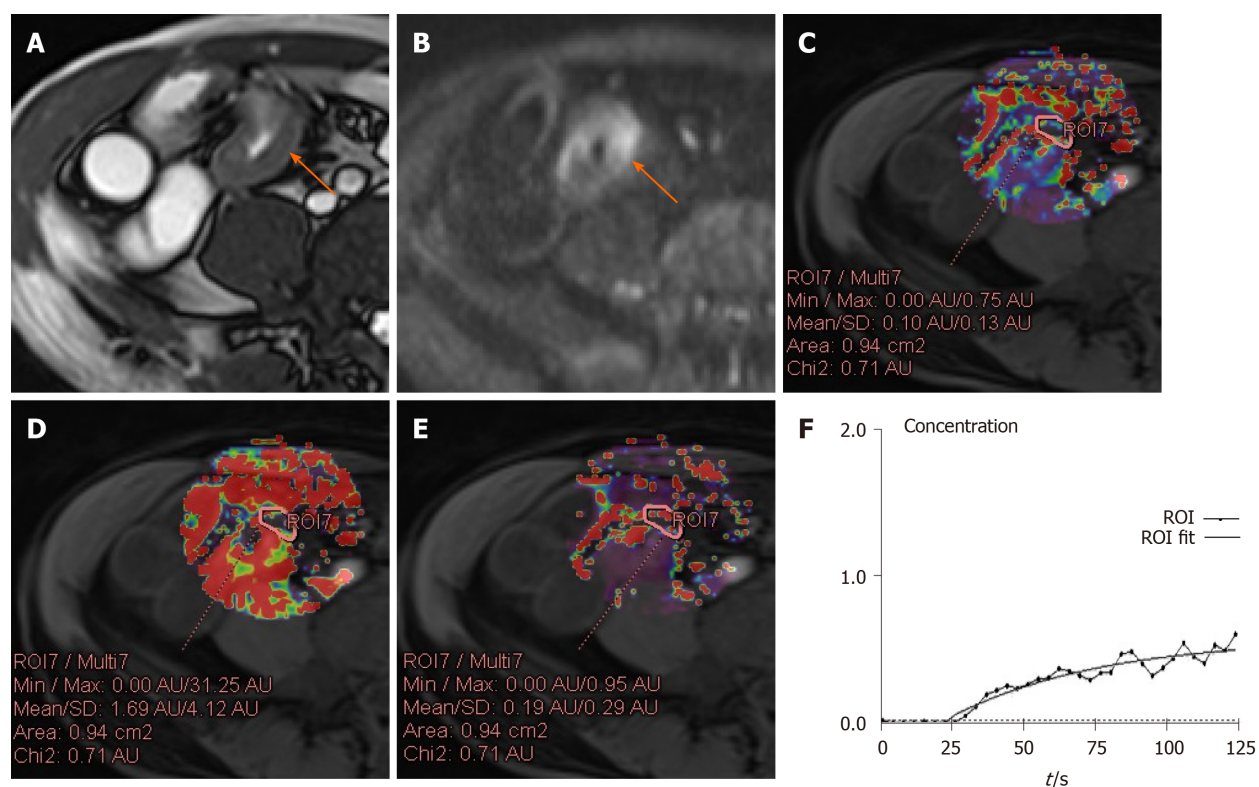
A 42-year-old male with remission of Crohn's disease in the terminal ileum and a Crohn's Disease Activity Index of 108 and Crohn's Disease Endoscopic Index of Severity of 2. A: Axial T2-weighted image shows mural thickening and hyperintensity in the terminal ileum (arrow); B: Axial diffusion-weighted imaging image ($b = 800 \text{ s/mm}^2$) demonstrates high signal (arrow) in the same bowel segment. Regions of interest (ROI) for the inflammatory bowel wall shows that apparent diffusion coefficient = $1.89 \times 10^{-3} \text{ mm}^2/\text{s}$; C: K^{trans} map is obtained through the relevant phase. The perfusion parameters of the ROI placed in the terminal ileum is calculated by TCM ($K^{\text{trans}} = 0.18 \text{ min}^{-1}$); D: K_{ep} map is obtained through the relevant phase. The K_{ep} of the ROI placed is 0.98 min^{-1} ; E: V_e map is obtained through the relevant phase. The V_e of the ROI placed is 0.19; F: The contrast concentration curve is plotted as ROI (line with circle) and fitted with the model (line). ROI: Region of interest.
